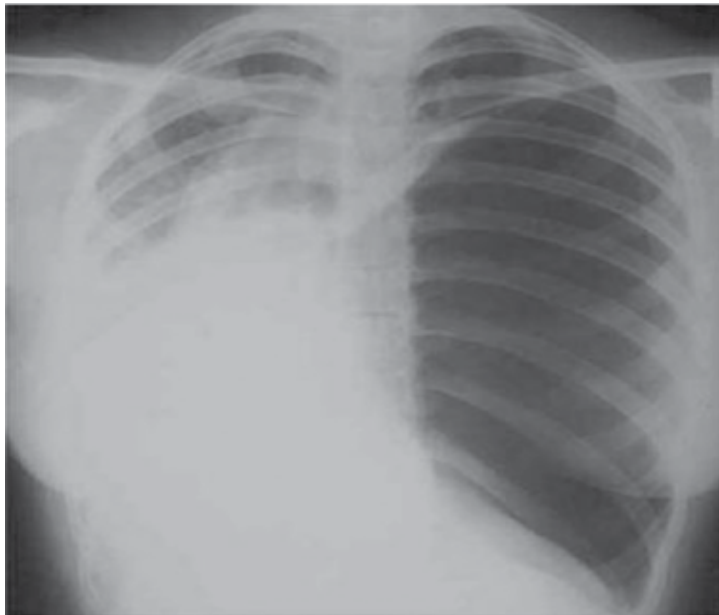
Radiograph of a patient with a large spontaneous tension pneumothorax.
